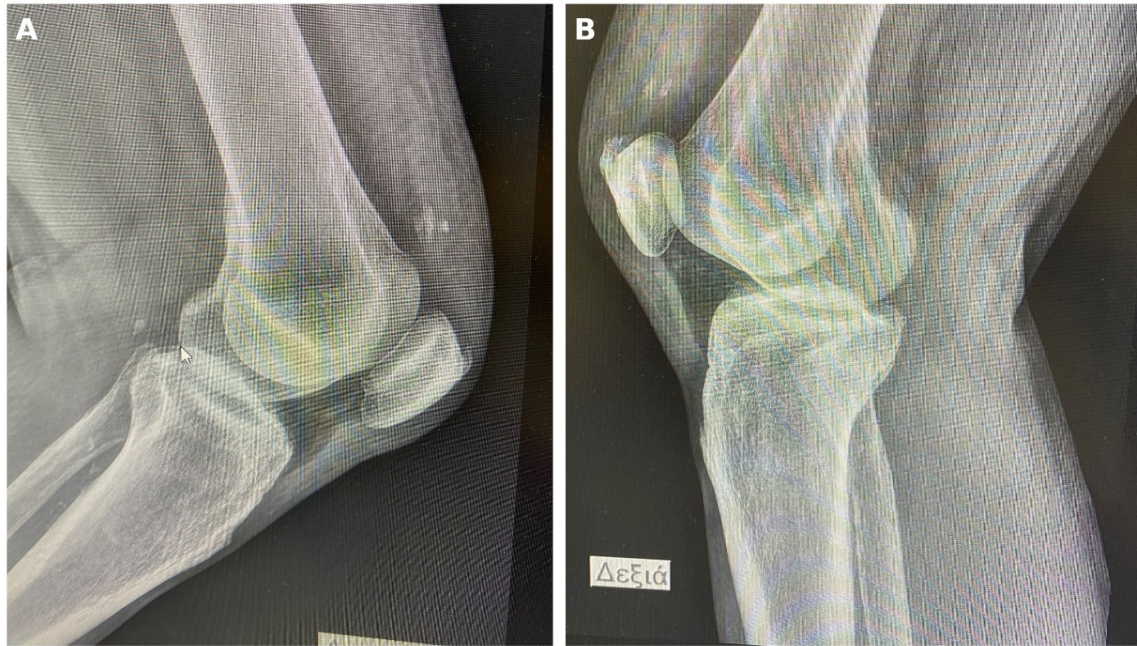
Preoperative lateral radiographs of both knees demonstrating bilateral patella baja and central calcific densities within the extensor mechanism.
